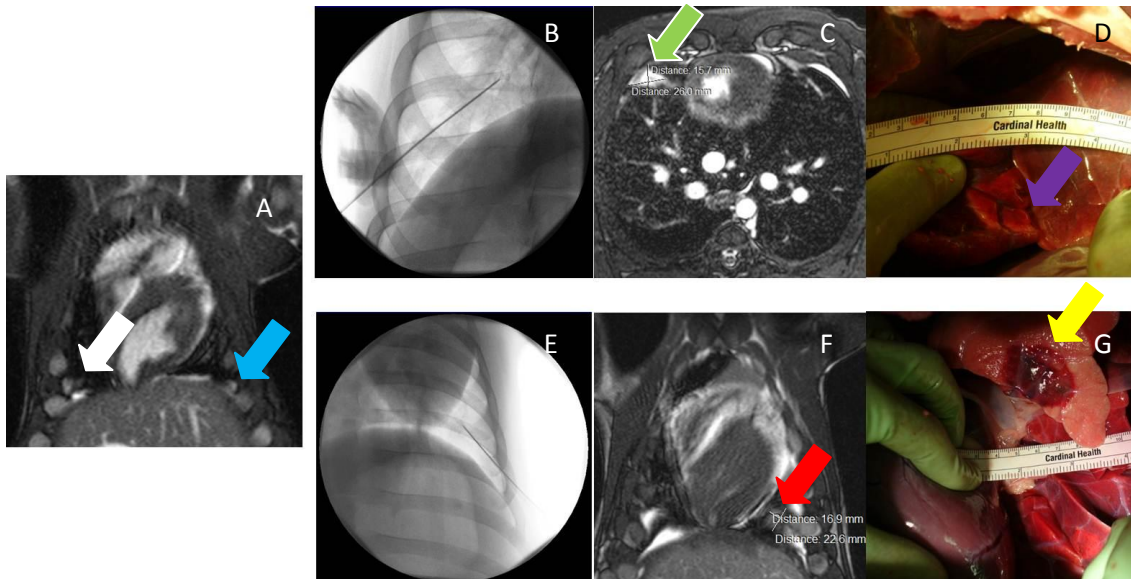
A: MR image (True FISP) used for treatment planning in the right (white arrow) and the left (blue arrow) sides. B: Needle placement in the right side (Fluoroscopy image); C: Post-ablation MRI (True FISP), showing the ablated area in the right side (green arrow); D: Necropsy image showing the ablated area in the right side (purple arrow). E: Needle placement in the left side (Fluoroscopy image); F: Post-ablation MRI (TrueFISP), showing the ablated area in the left side (red arrow); G: Necropsy image showing the ablated area in the left side (yellow arrow).
